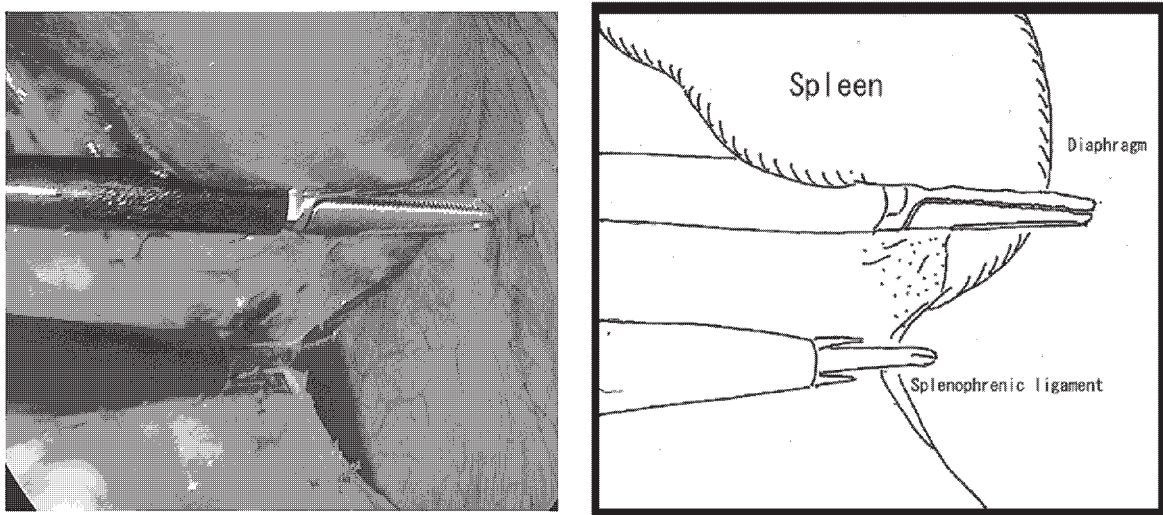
The splenophrenic ligament was divided using ultrasonic laparoscopic coagulation shears.
